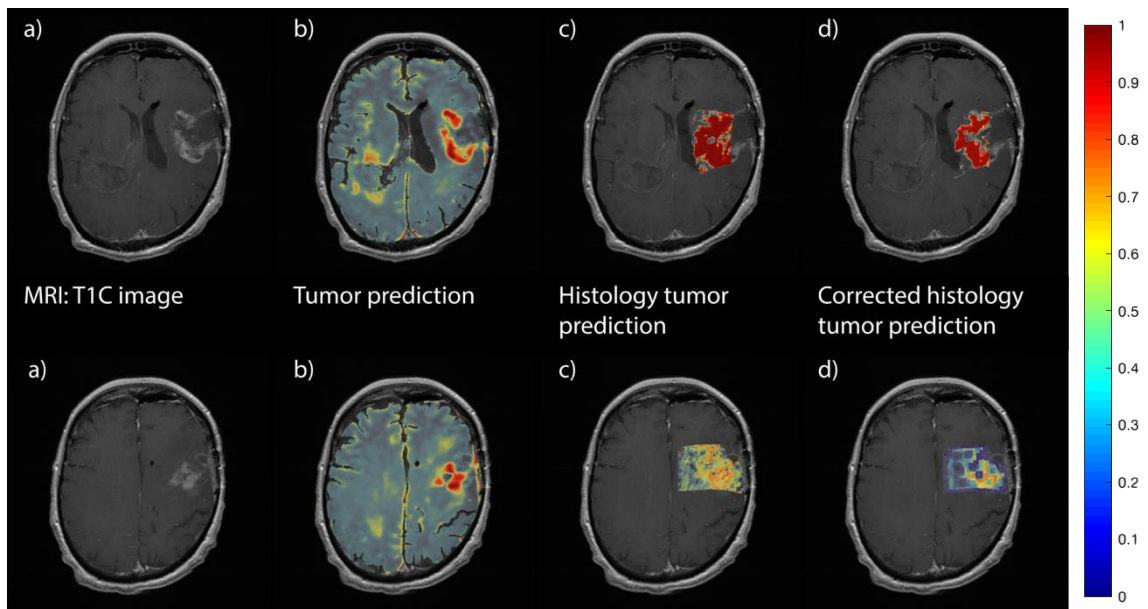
shows two examples of the final output. This is an example of tissue that has a clearly defined tumor, highlighted in the T1C scan, but also identified by the MRI model.
